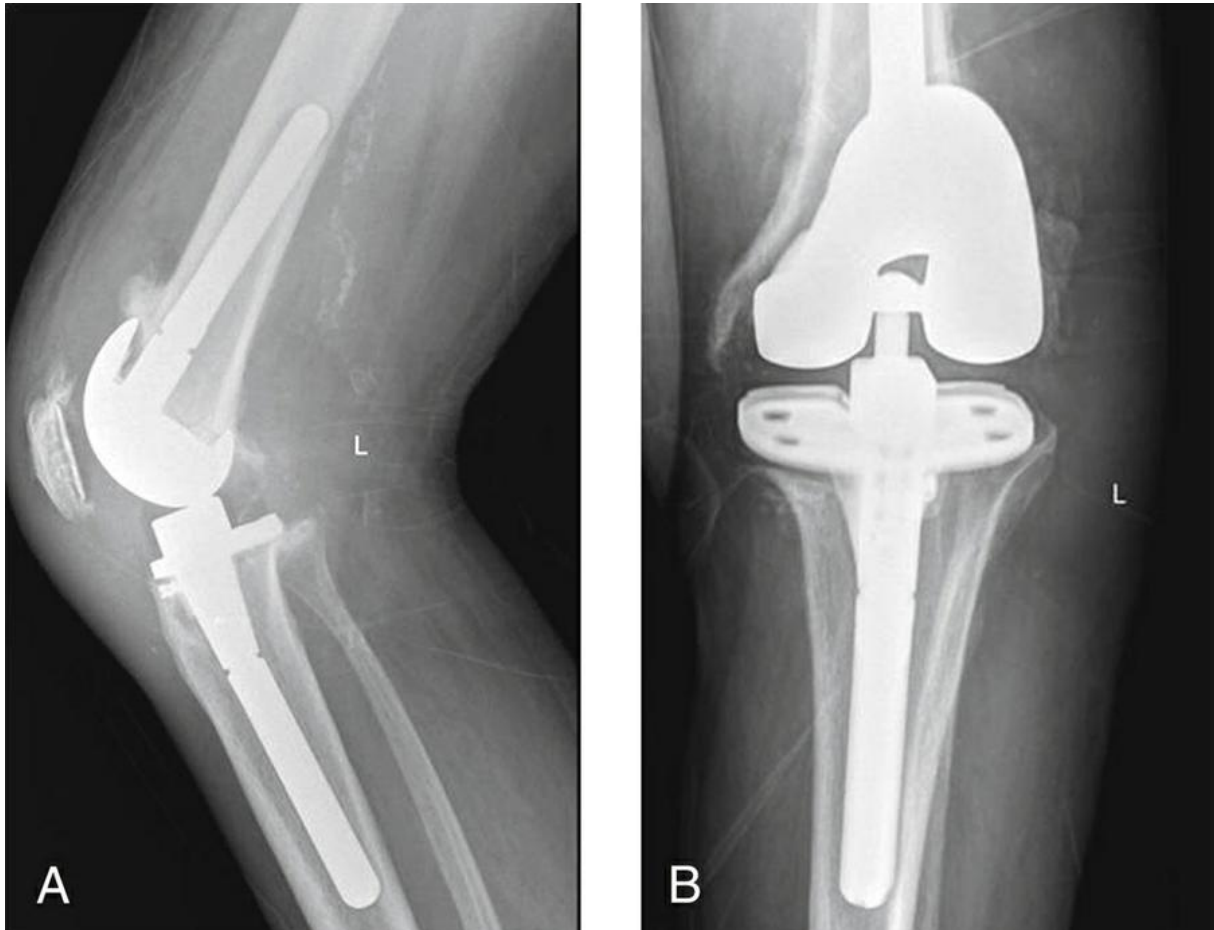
Lateral (A) and AP (B) radiographs of the knee in a patient with periprosthetic joint infection demonstrating cortical resorption, focal osteolysis, and periosteal reaction.
